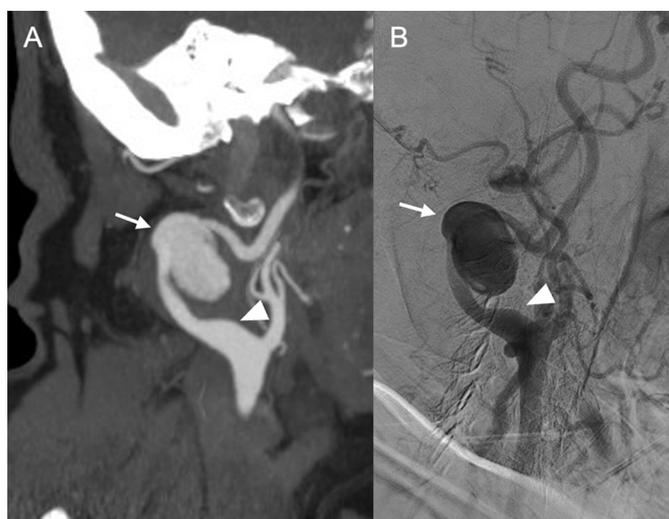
66-year-old female smoker with a history of arterial hypertension, dyslipidaemia, pulmonary embolism and deep vein thrombosis who, for months has been able to palpate a pulsatile right laterocervical mass, with no apparent cause. An ultrasound scan was performed at her health centre, detecting an aneurysmal dilation of the right internal carotid artery. Sagittal maximum intensity projection reconstruction of supra-aortic trunk CT angiography in arterial phase (A) confirming the presence of the right internal carotid artery-dependent pseudoaneurysm (arrow), and arteriogram (B) used for endovascular treatment with stenting. Both images show vascular loops and segmental dilatations (arrowhead) involving bilateral vertebral and carotid territories, which in this patient had not been attributed to any disorder until now.
